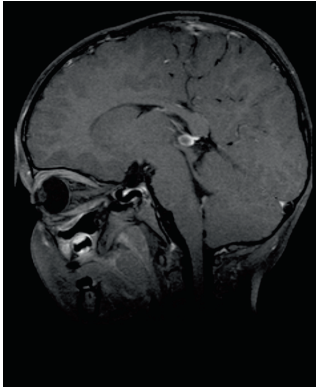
Patient 10. Contrast-enhanced T1-weighted MR image of a 34-month-old patient with nonhereditary retinoblastoma with a pineal cyst, with a diameter of 7 mm.
